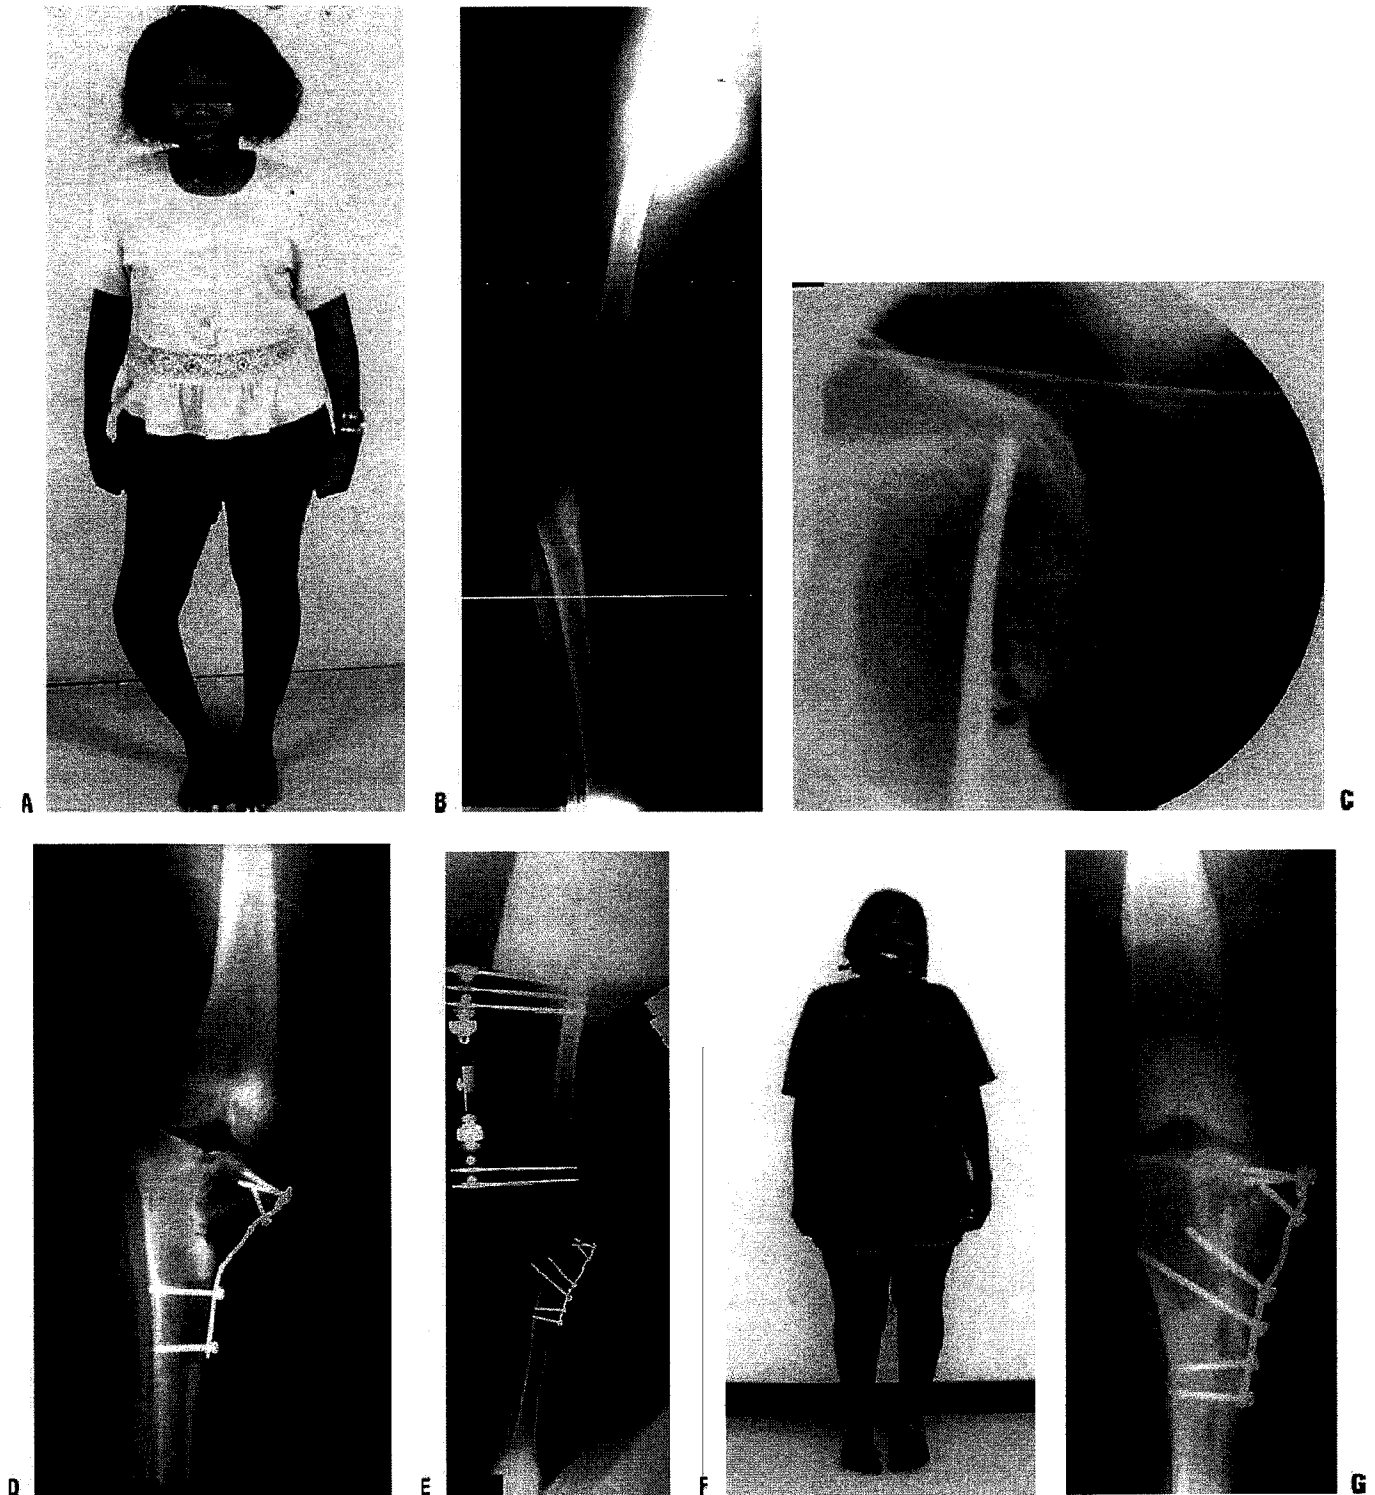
Treatment of stage V Blount disease. A: Severe deformity and a lateral thrust are noted clinically. B: Blount disease that progresses to physeal bar formation results in severe depression of the medial metaphysis. Valgus may develop in the distal femur because of overgrowth of the medial femoral condyle. Restoration of medial physeal growth is not possible. C: Image intensification is useful to control the direction of the medial tibial plateau osteotomy. The cut begins at the apex of deformity in the medial cortex and is completed between the tibial spines. D: A cortical strut is used to support the elevated plateau. E: Osteotomy of the tibia or femur, or both, is performed to correct residual tibial varus or femoral valgus. F: Normal anatomic and mechanical alignment can be achieved with this approach. Residual limb-length inequality can be managed by contralateral epiphysiodesis if needed. G: Radiographic appearance after healing of the osteotomies shows restoration of joint orientation and mechanical alignment.
